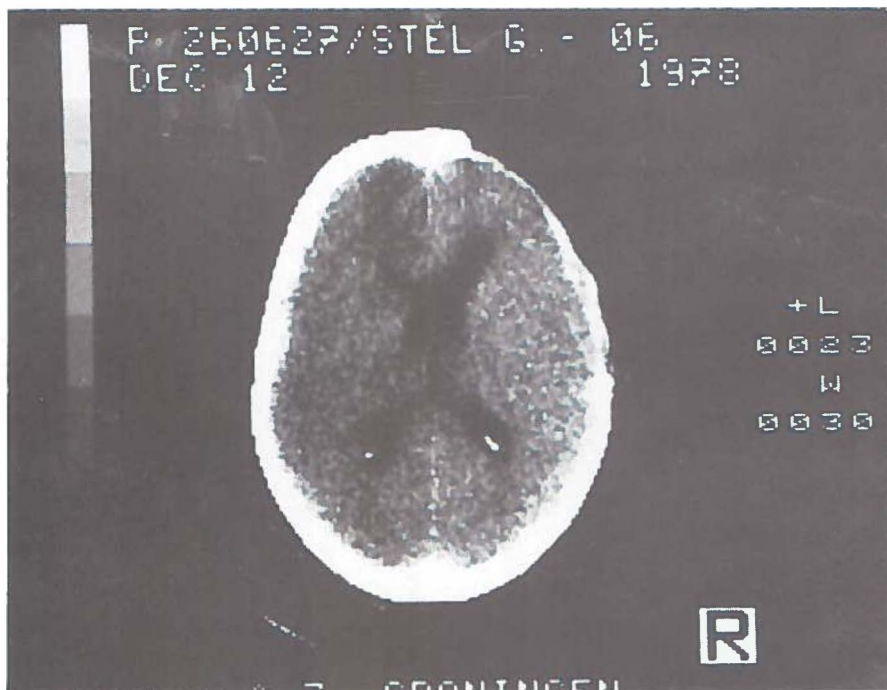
Computerised tomography (CT) scan twenty days after the second operation showing a left frontal infarct.
